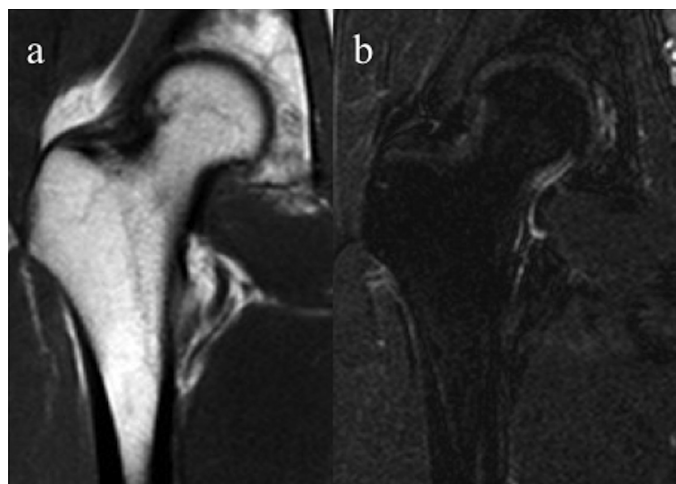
a,b Magnetic resonance images (MRI) performed at the end of a 2-month period of conservative therapy. (a) Coronal T1-weighted image. The band previously seen on MRI is no longer evident. (b) Coronal short-tau inversion recovery (STIR) sequence image. The band previously seen on MRI is no longer evident.
